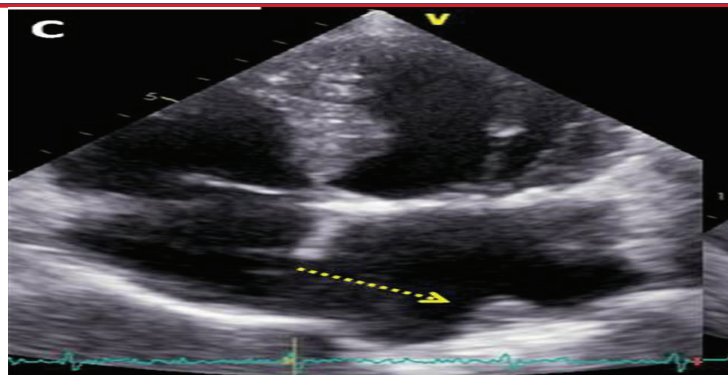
Transthoracic echocardiography (TTE) shows reduction in thrombus size at 30 days.
